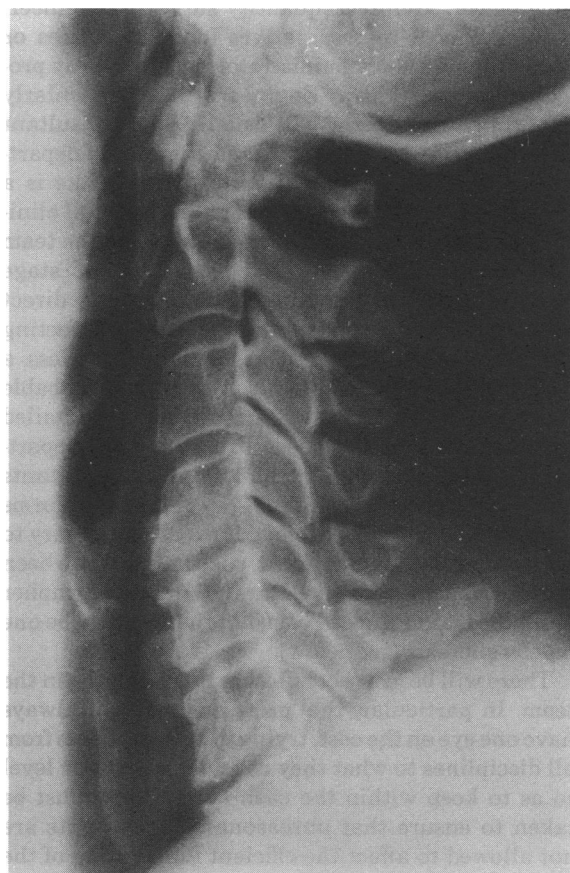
Initial X-ray showing spondylosis with no evidence of fracture or subluxation.
